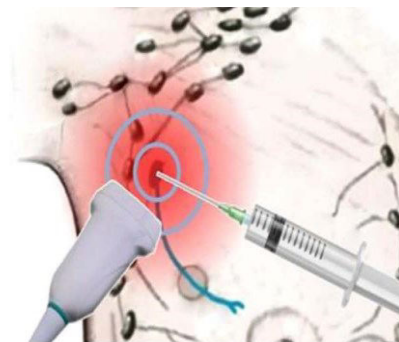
Injecting Blue Dye as a tracer in Photoacoustic Tomography–Ultrasound (PAT-US) imaging pinpoints the SLN [8].
